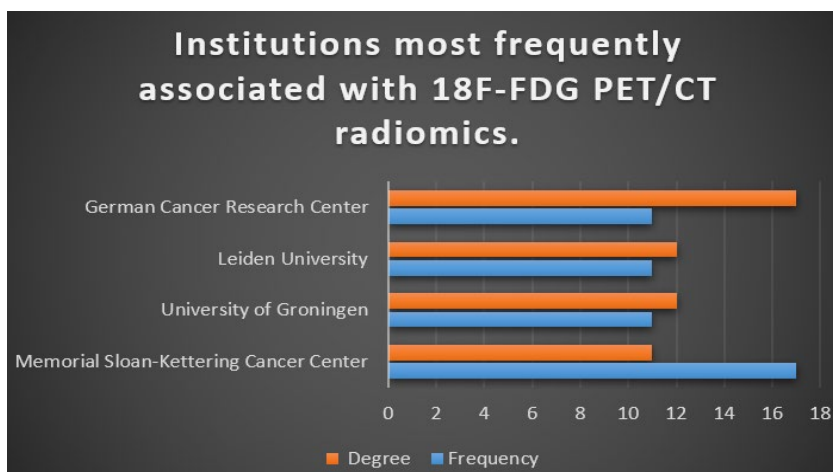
(a) Institutions most frequently associated with 18F-FDG PET/CT radiomics
